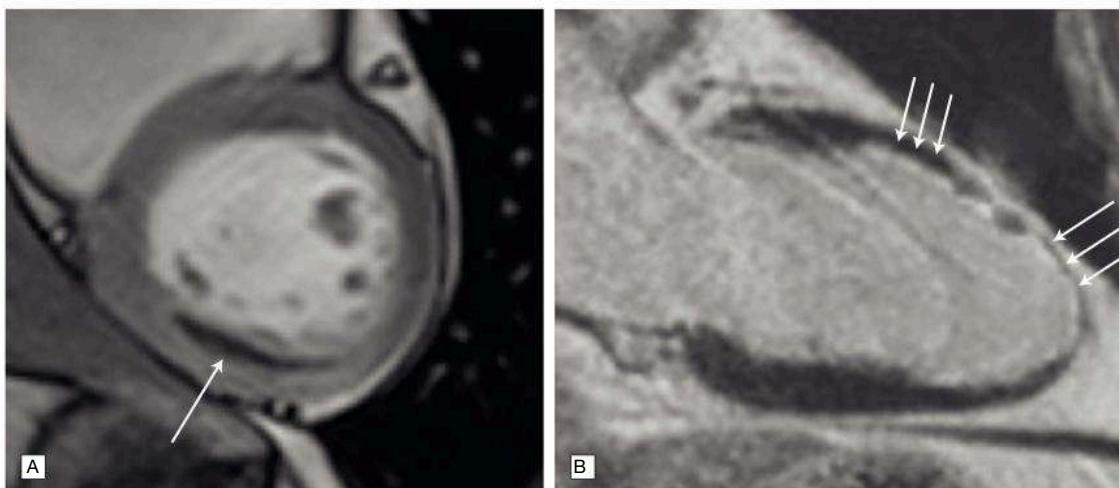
Cardiac magnetic resonance imaging. A Recent inferior myocardial infarction with black area of microvascular obstruction (arrow). B Old anterior myocardial infarction with large area of subendocardial delayed gadolinium enhancement (white area, arrows).
